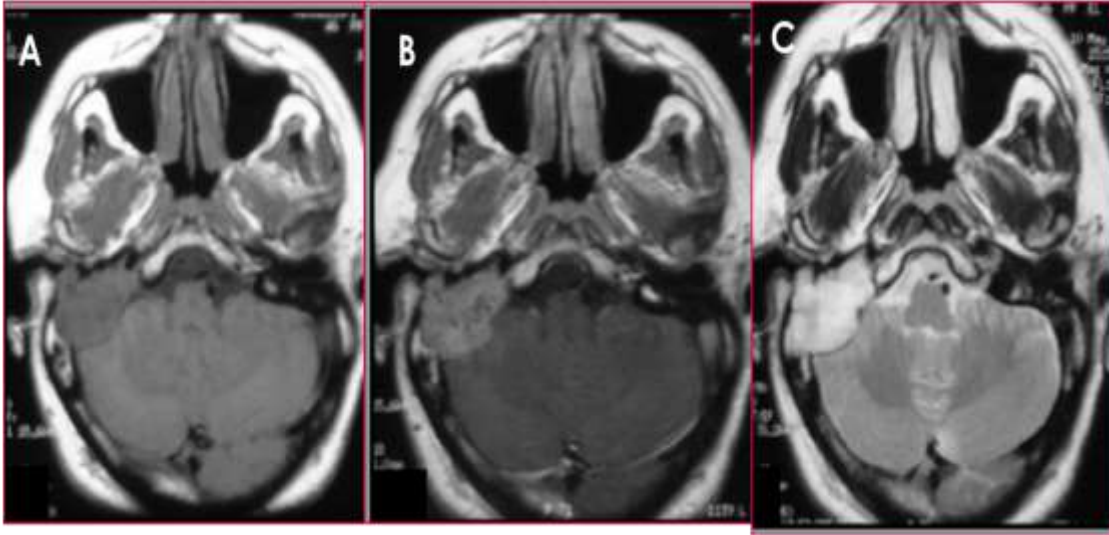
(A, B and C): MRI showing a right jugulocarotidian paraganglioma in T1, Flair and T1 sequence after injection of gadolinium.
